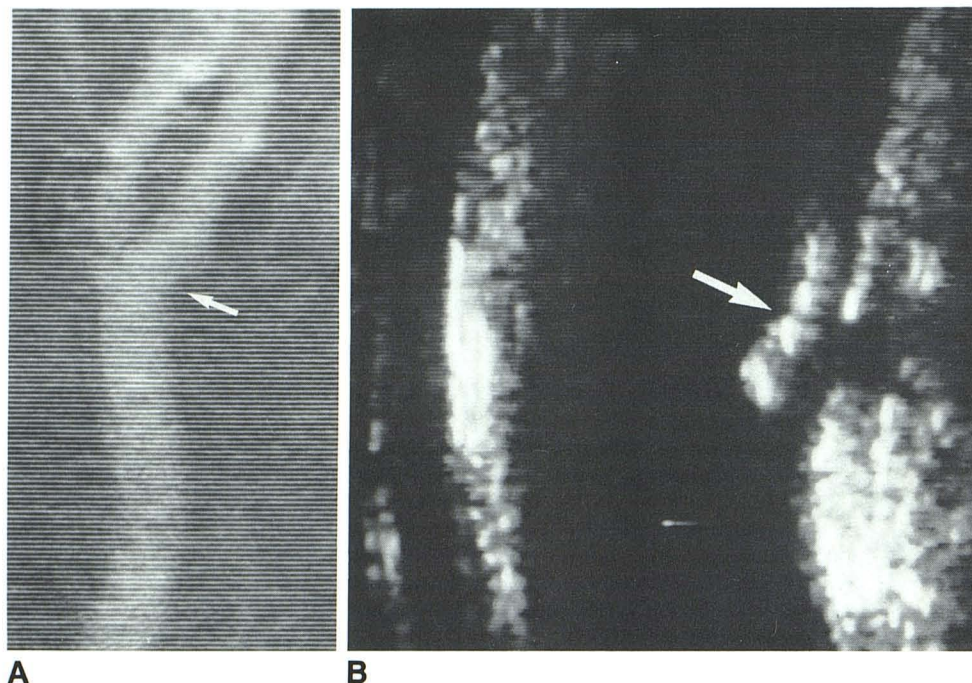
A, DSA. Narrowing of distal common and internal carotid arteries by long plaque (arrows). Associated stenosis was considered to be in 50%–75% range of diameter reduction. B, Sonogram. Plaque (short arrows) and localized region of severe stenosis within diseased segment (long arrow). Doppler signals at this site were consistent with severe stenosis (>75% diameter reduction). CC = common carotid artery; IC = internal carotid artery. Skin line is on reader's left.
